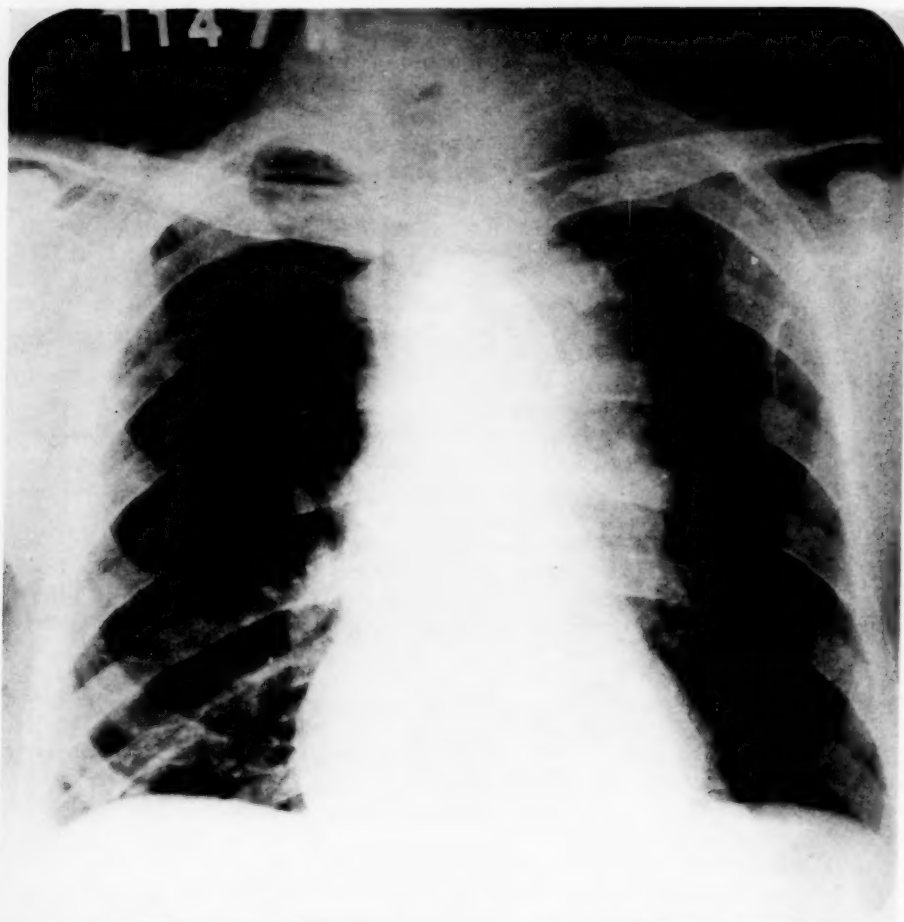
Six foot roentgenogram of chest showing fusiform dilatation of the descending aorta. The trachea deviated toward the right. No enlargement of the heart.
